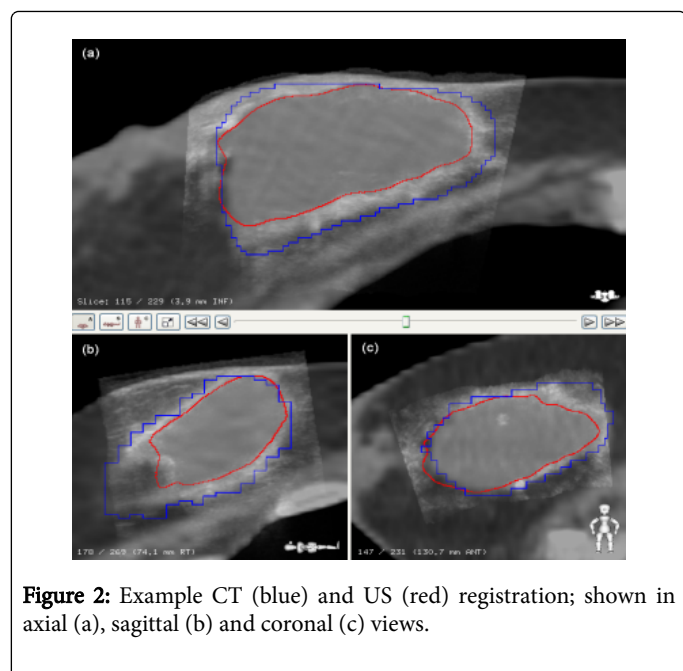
Example CT (blue) and US (red) registration; shown in axial (a), sagittal (b) and coronal (c) views.
